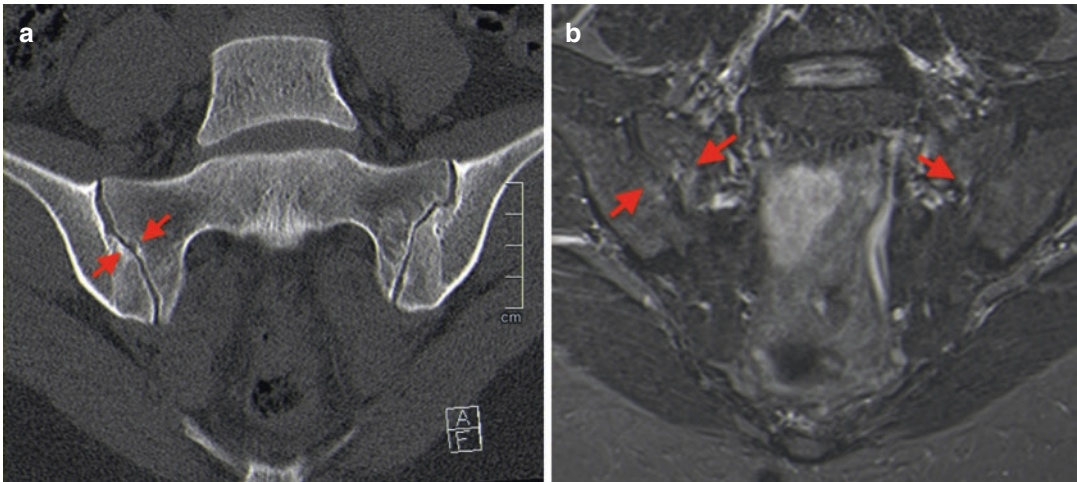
(a, b) 25-year-old female, gymnast and contemporary dancer. (a) coronal CT image with cortical irregularity/minor erosions, subtle space joint changes and mild sclerosis more evident on the right SIJ (red arrows). (b) Coronal fat-suppressed T2-weighted image on the same
